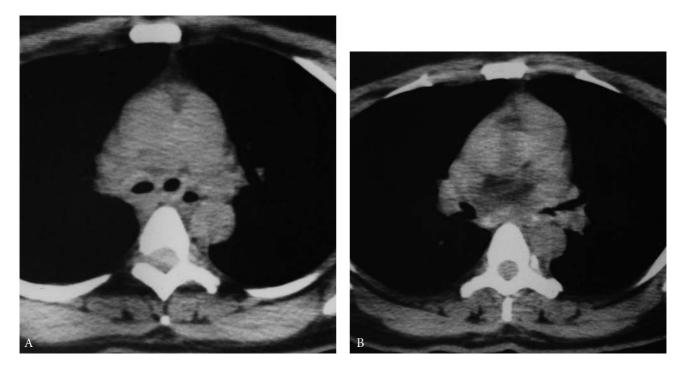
Diffuse tracheobronchial stenosis in sarcoidosis. Computed tomography scans through the main bronchi (A) and left upper lobe bronchus (B) reveal diffuse bronchial wall thickening and calcification. Calcified subcarinal lymph nodes are noted.
